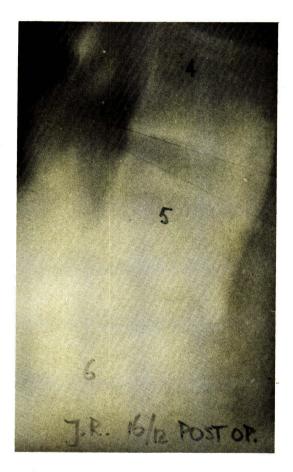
X-rays appearance of mon-union of fusion
